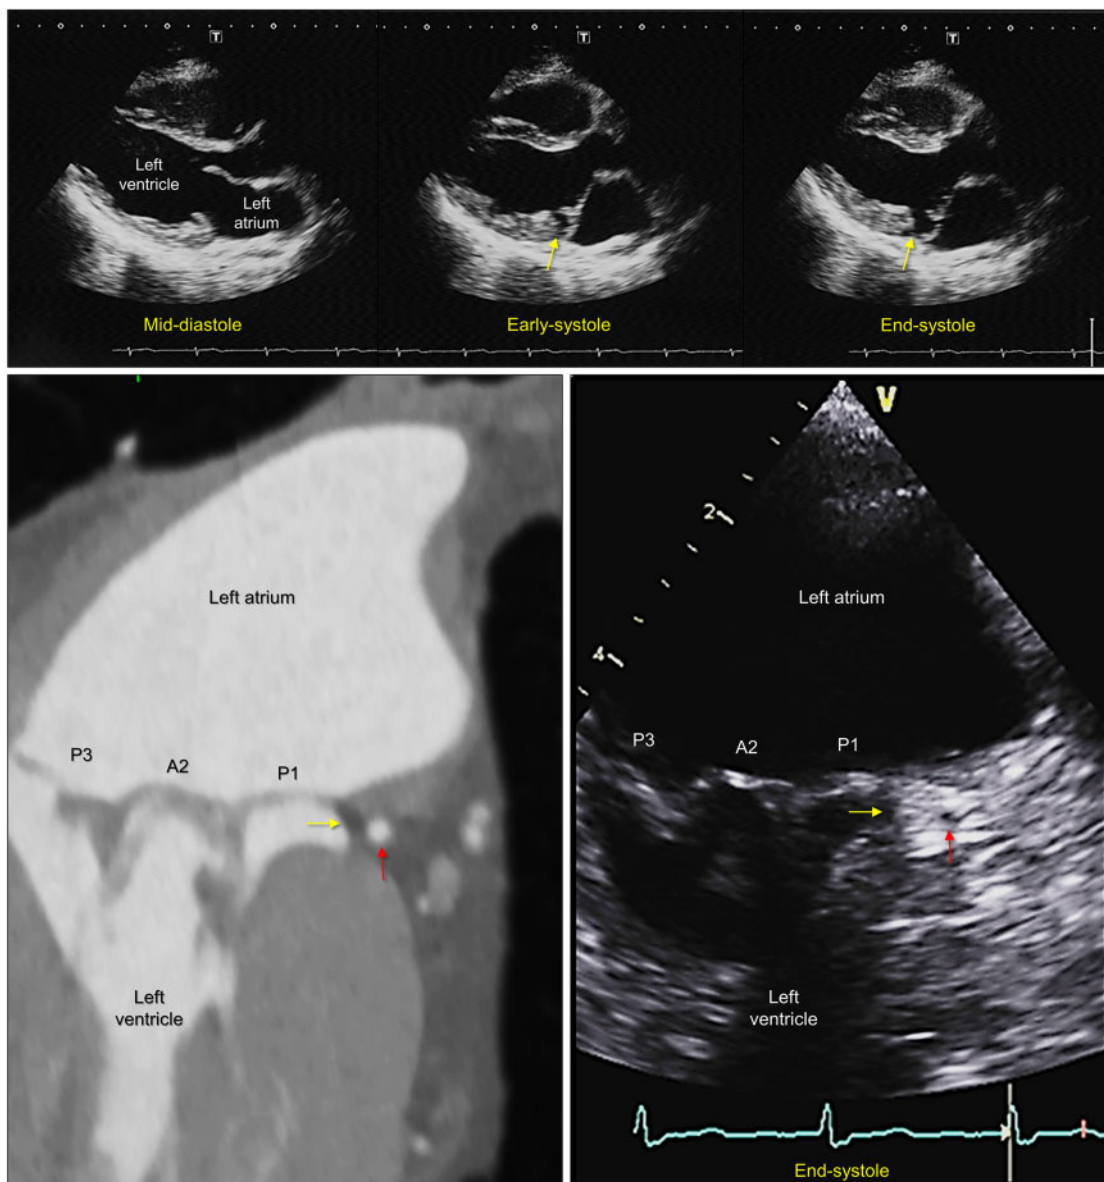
Echocardiographic images of disjunction. Serial transthoracic echocardiographic images (upper panels). Disjunction (yellow arrows) at the infero-lateral region is visible during systole. Lower panels show transesophageal images showing disjunction (yellow arrows) at the subvalvar region supporting the P1 scallop of the posterior mitral leaflet. Red triangles indicate the left circumflex artery. The sectional plane is replicated using cardiac computed tomography obtained from the same patient. The difference in spatial resolution and field of view is evident.
